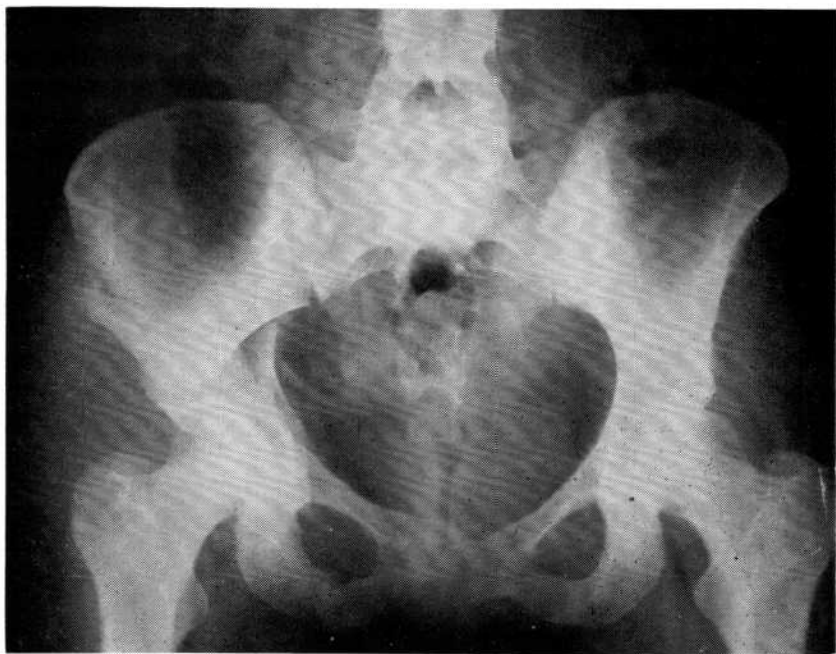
Later X-Ray of Patient in Fig. I. Dead Fetus was expelled one week after accident. No Abruptio. Mother recovered.
